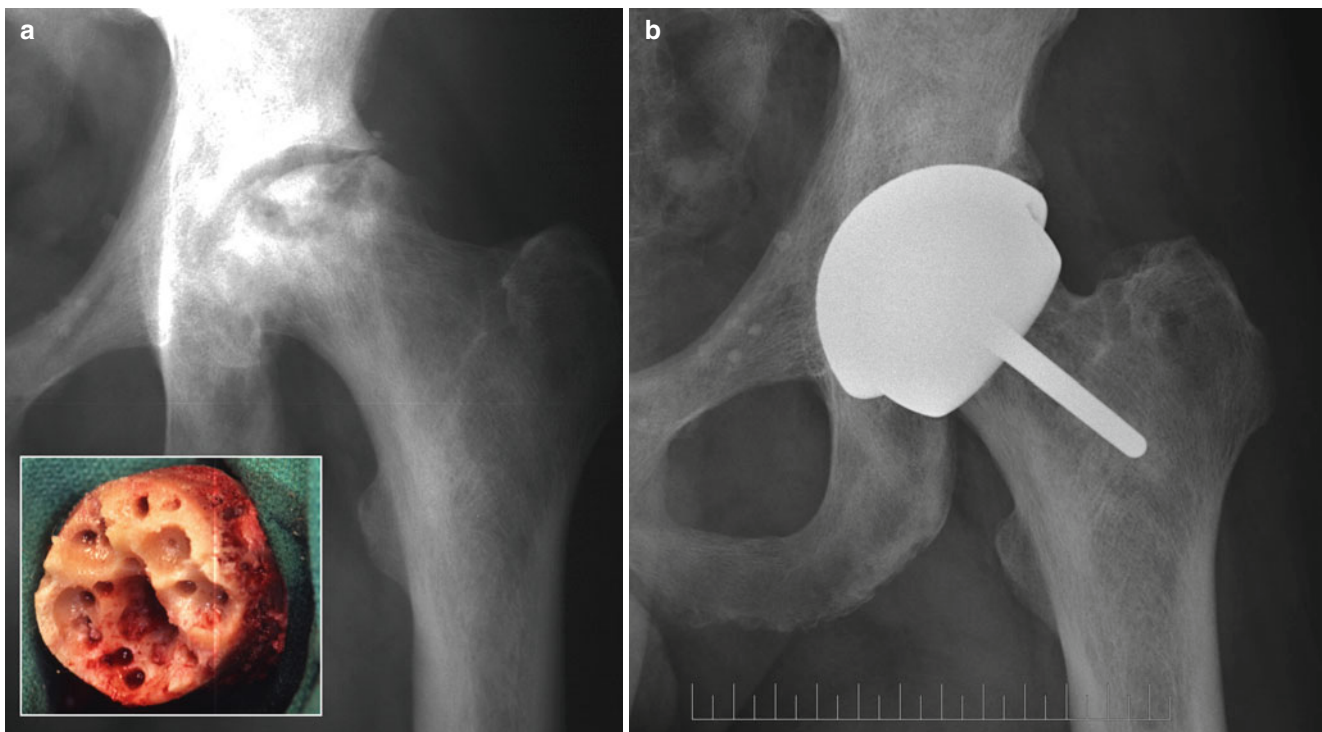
(a) Anteroposterior radiograph of a 46-year-old bus driver with a history of sickle cell disease and Ficat stage IV osteonecrosis of the left hip. The femoral head defects were extensive as shown on the intraoperative photograph of the femoral head after preparation (inset).
